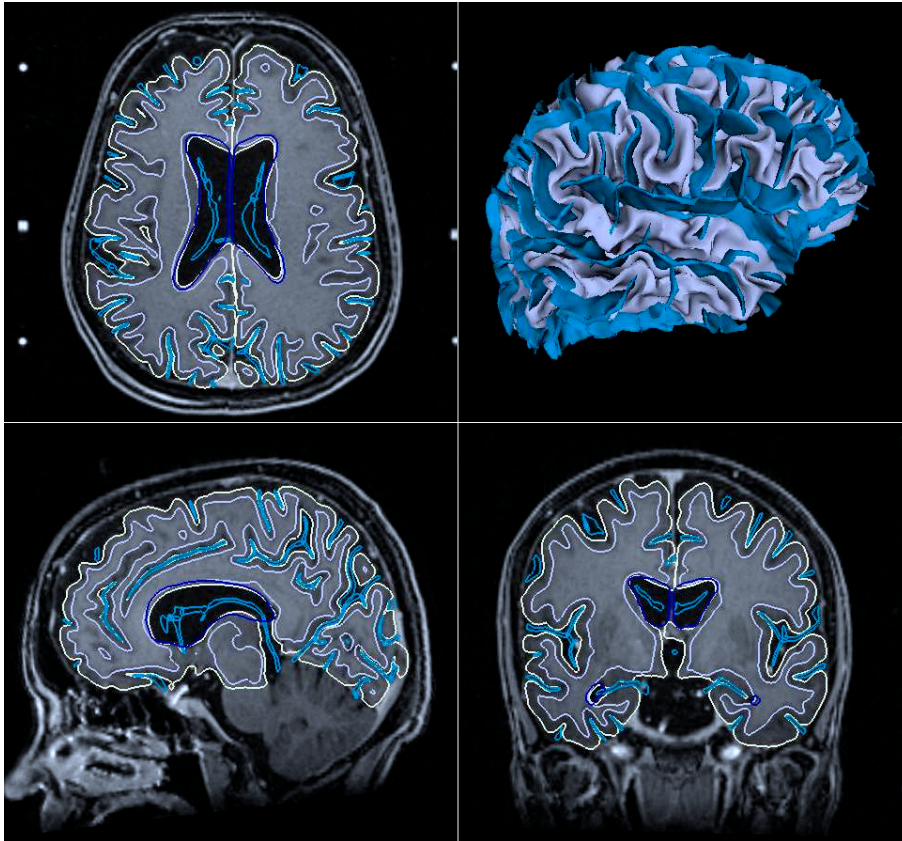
Brain MRI in transverse (top left), sagittal (bottom left), coronal (bottom right) and 3D view (top right). The following structures and interfaces has been segmented:
